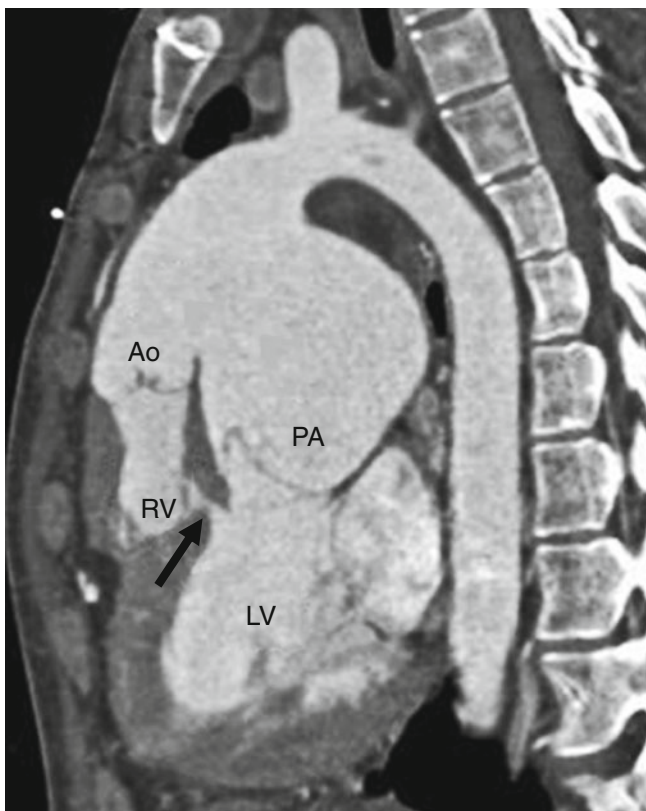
Damus–Kaye–Stansel operation. An oblique sagittal CT image in a patient with tricuspid atresia and L-transposition of the great vessels. The aorta (*Ao*) which arises from the hypoplastic right ventricle (*RV*) has been connected to the pulmonary artery (*PA*) arising from the left ventricle (*LV*). A septal defect (*arrow*) provides communication between the two ventricles
